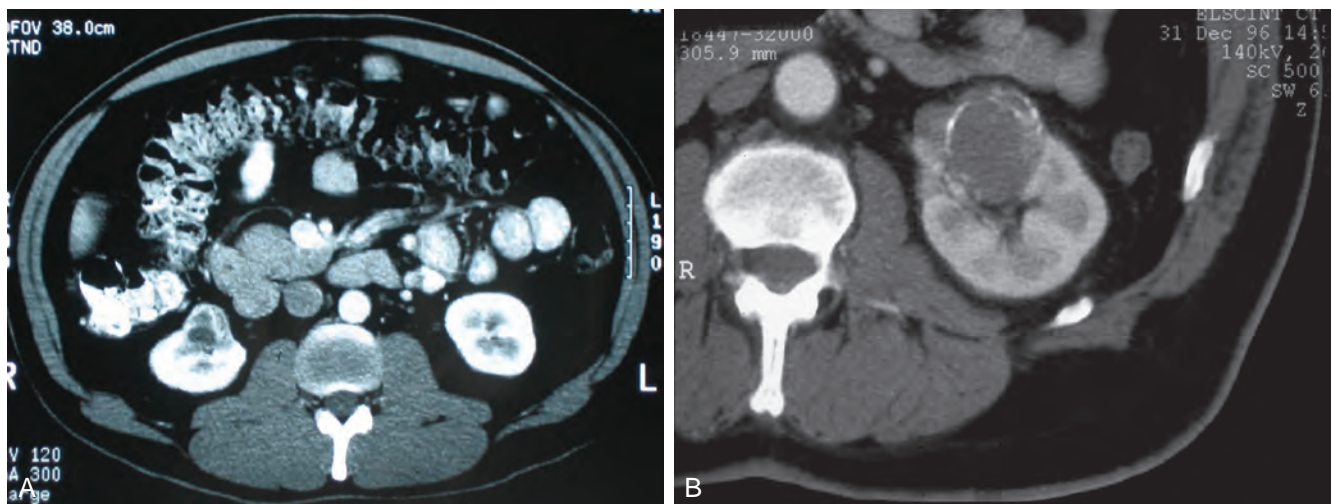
Bosniak category III cysts. A, Computed tomography (CT) scan shows complex right renal cyst with thick and irregular septa and inhomogeneous character. B, CT scan shows somewhat thick-walled, complex left renal cyst also exhibiting irregular calcification and moderate heterogeneity. (Courtesy Dr. Terrence Demos, Maywood, IL.)
